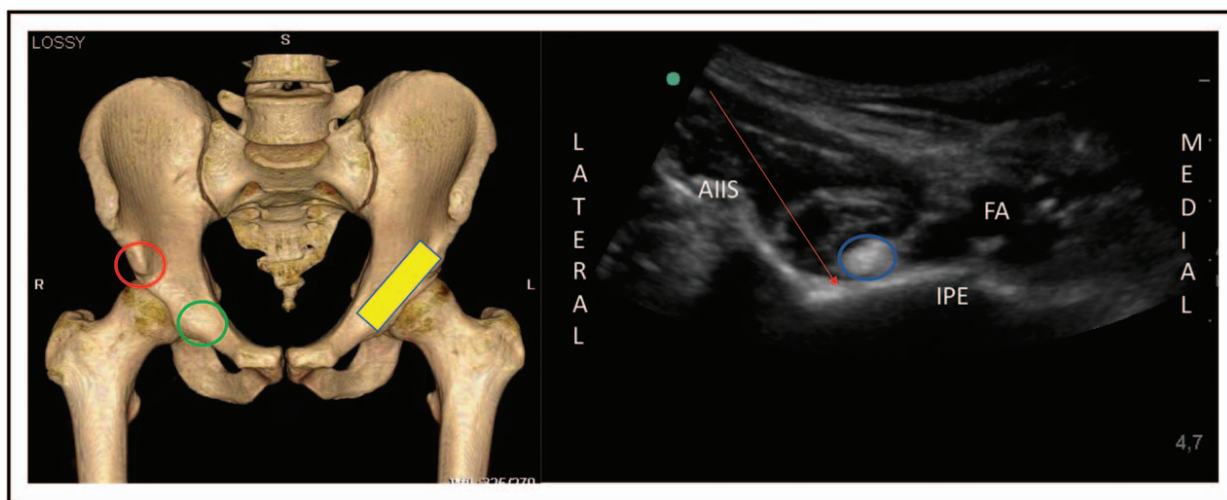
Anatomic landmarks for Pericapsular nerve group (PENG) block. Left is the skeletal image showing the position of the ultrasound probe (yellow). Red circle: anterior inferior iliac spine, Green circle: iliopubic eminence. Right figure is the corresponding ultrasound image. AIIIS: anterior inferior iliac spine, IPE: iliopubic eminence, FA: femoral artery, Blue circle: psoas tendon, Red arrow: in plane needle trajectory from lateral to medial. Reprinted with permission from Philip Peng Educational Series.
